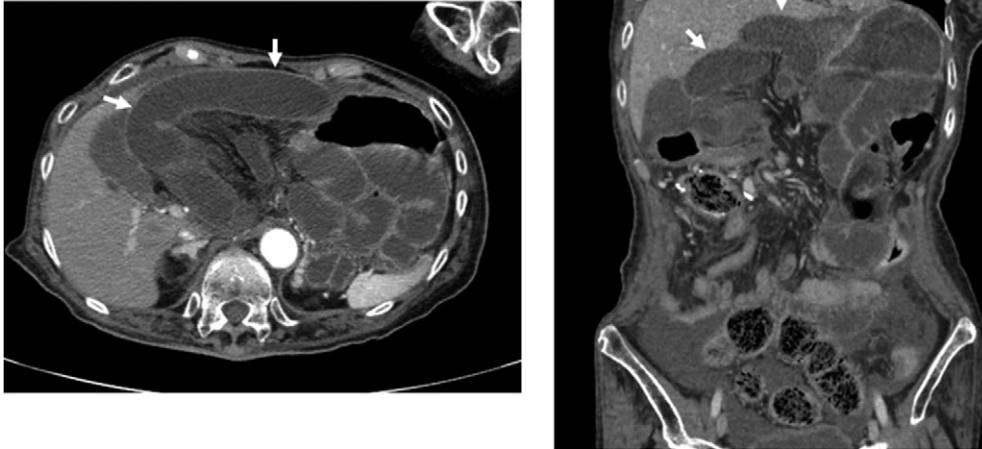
Preoperative CT scan revealed an internal hernia (arrow).
